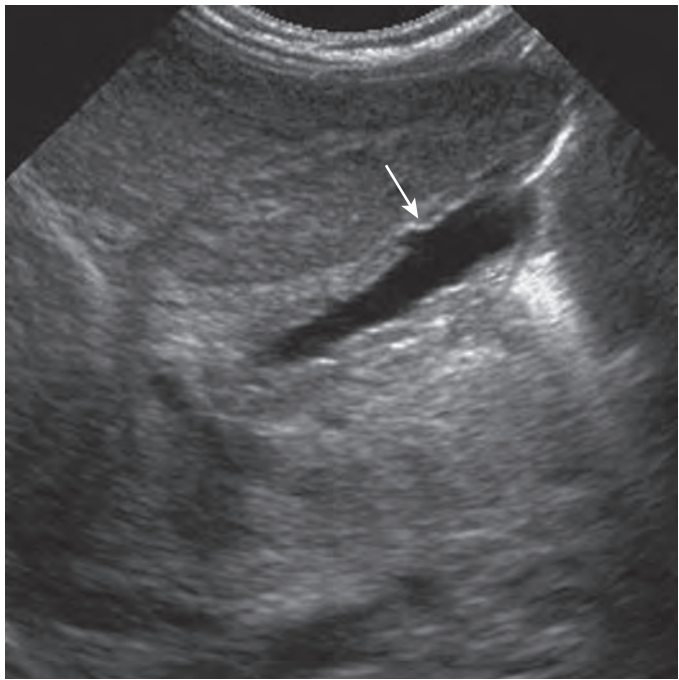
Biliary atresia: gallbladder ghost triad on ultrasound. The combination of an atretic gallbladder with irregular mucosa and wall contour (arrow) has been called the gallbladder ghost triad. It is associated with biliary atresia. (Courtesy Myung-Joon Kim, MD, Yonsei University College of Medicine, Severance Hospital, Seoul, Korea.)
